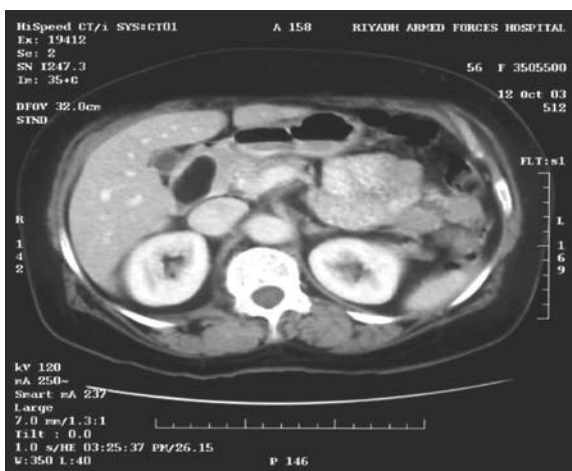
CT scan appearance of duodenal lipoma.
